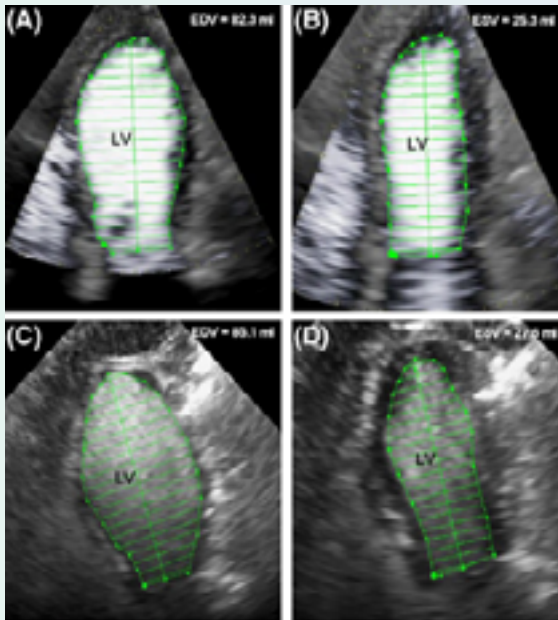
Left ventricular (LV) end-diastolic volume (EDV) and end-systolic volume (ESV) images in the apical four-chamber view showing LV HD-Flow (A and B), and LV contrast (C and D) in a patient with normal systolic function. (Reproduced from Echocardiography 2019 Mar;36(3):546-557)
